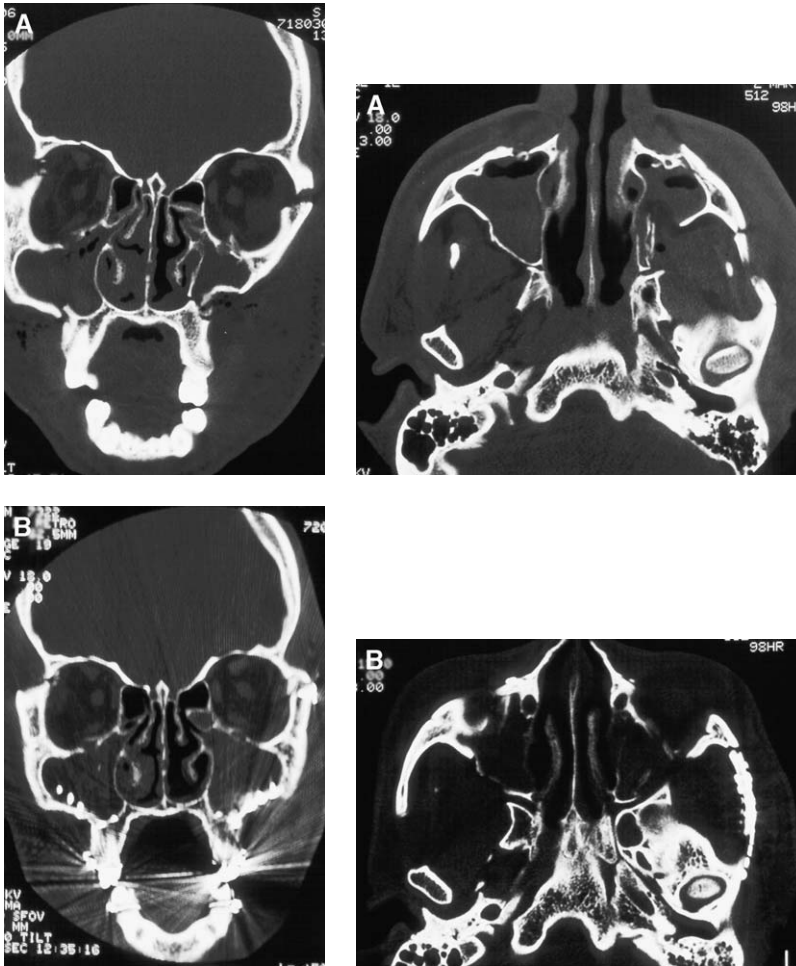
(A) Coronal and axial CT images demonstrating left Le Fort III and right Le Fort II level injuries with severe left zygomatic arch comminution. (B) Following endoscope-assisted repair, anatomic realignment of midfacial anatomy and restoration of preinjury occlusion can be seen. (From Czerwinski M, Lee C. Traumatic arch injury: indications and an endoscopic method of repair. *Facial Plast Surg* 2004;20(3):231–8, with permission.)
